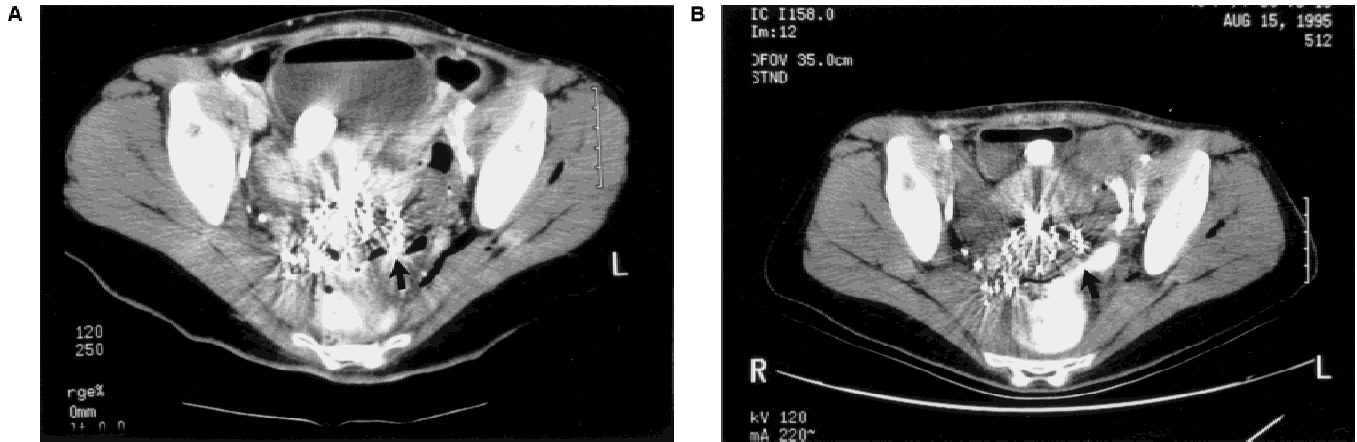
A: Axial CT identifying needles penetrating sigmoid (arrow) with subsequent removal prior to loading (B).
